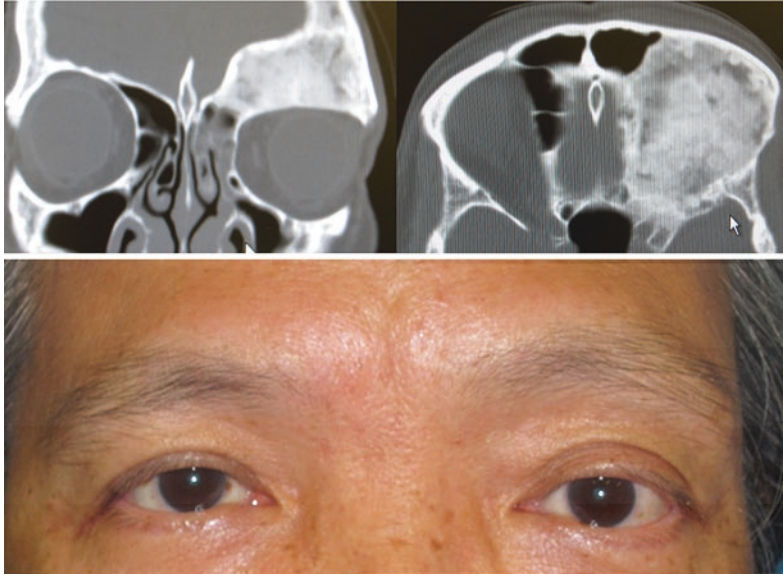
Left-sided frontal bossing, proptosis, hypoglobus due to mono-ostotic fibrous dysplasia affecting the frontal bone. Note the typical ground-glass appearance on CT scan
